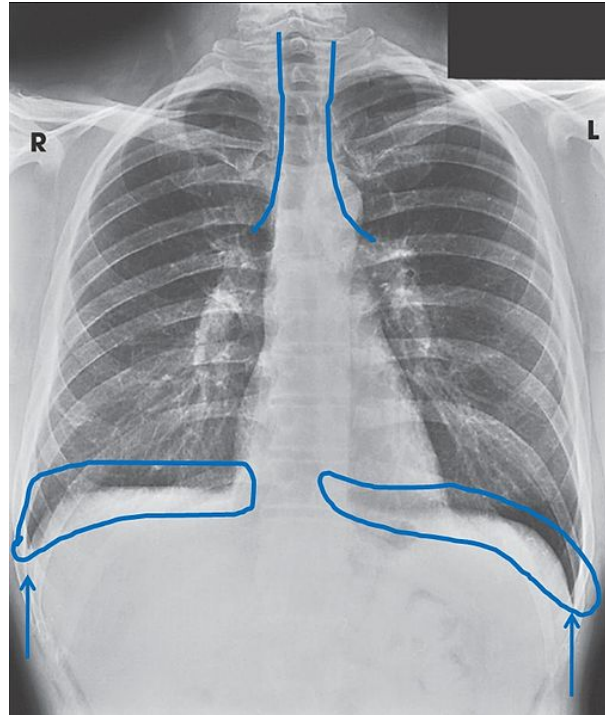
Radiograph showing air-filled trachea and lungs, diaphragmatic domes, mediastinal structures, and vascular markings. Arrows indicate costophrenic angles. Source: US Army medical training course. Wikimedia Commons.
